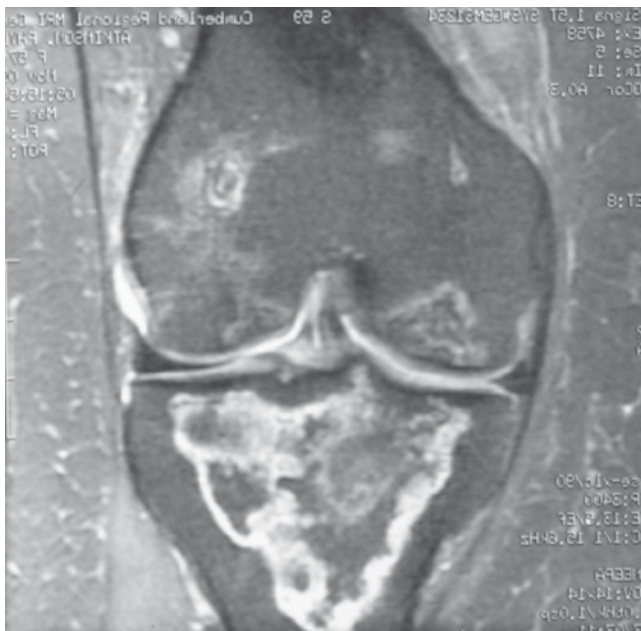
A T2 weighted MRI showing infarcts of both the femur and tibia. The tibial infarct shows a high signal demarcating the area of dead bone
